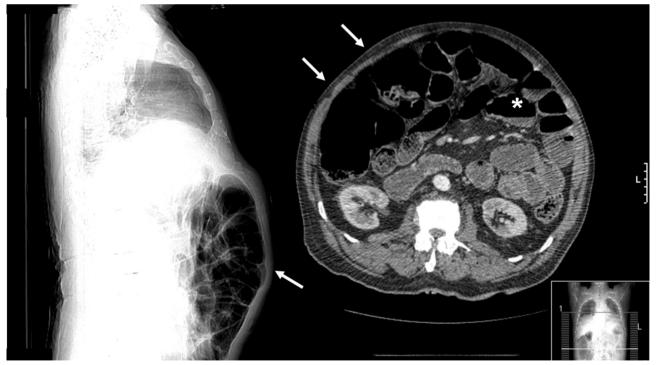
Abdominal CT scan showed generalized dilatation with hydroaerial levels in the small bowel.
